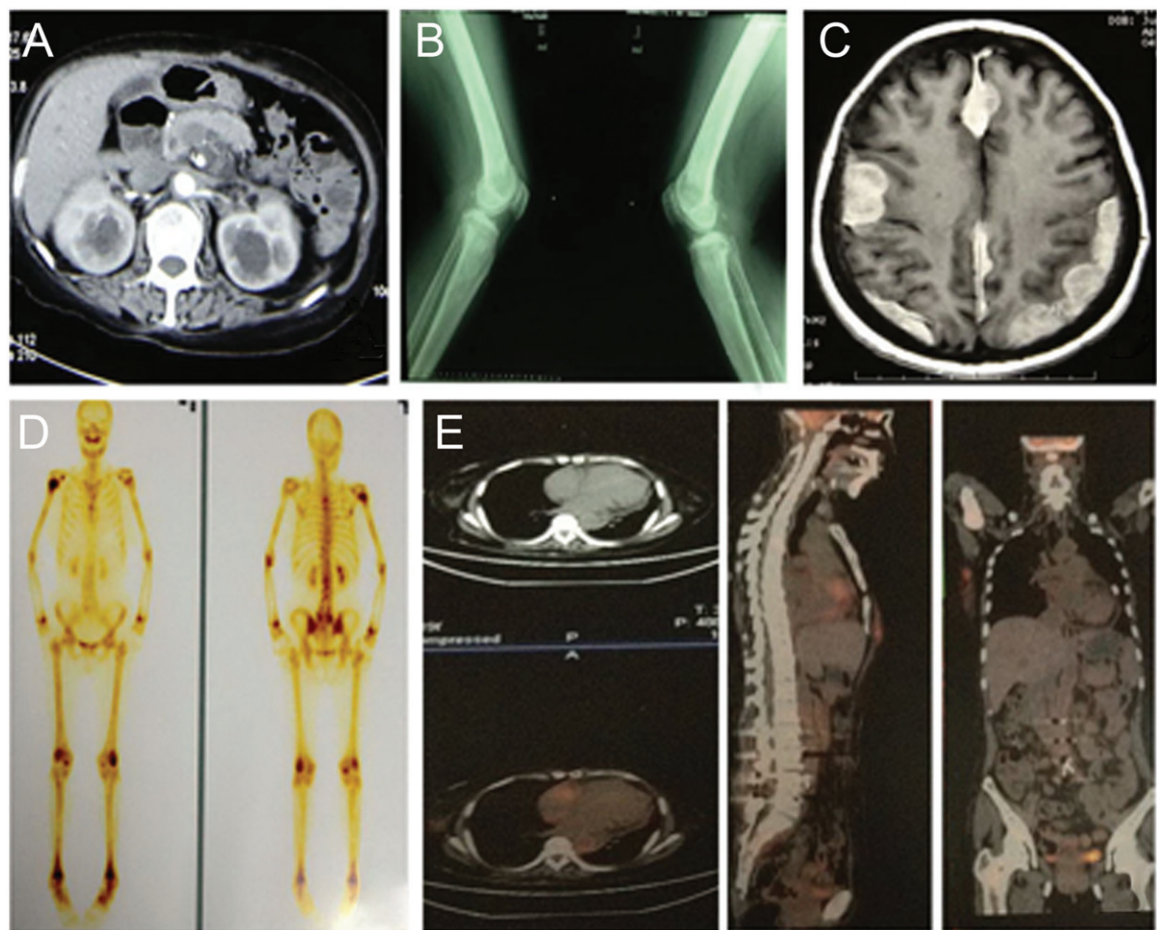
Initial radiographic examination of the patient before treatment. (A) Abdominal computed axial tomography scan of patient. (B) Plain x-ray of lower limbs in the patient. (C) Brain MRI with gadolinium enhancement. (D) A 99 mTc-MDP bone scintigraphy of planar whole body scan in anterior and posterior views. (E) 18F-FDG PET/CT examination showed multiple intense focal uptakes throughout the whole body with cardiac involvement.
